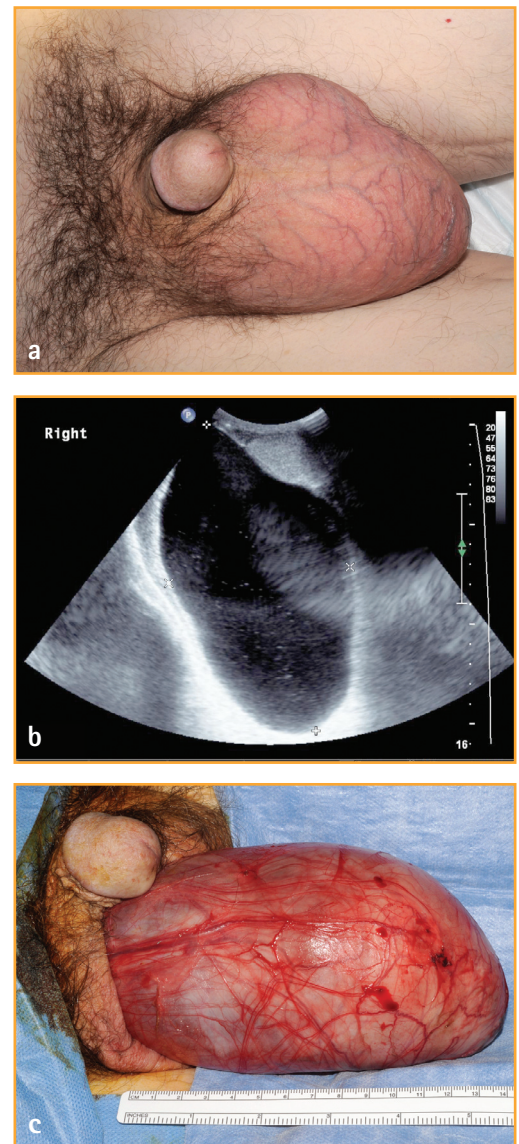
(a) 75-year-old man with 15cm right epididymal cyst; (b) seen at ultrasound; (c) seen during surgical excision. Usually epididymal cysts are small and palpable separate to the testis, most commonly at the epididymal head
